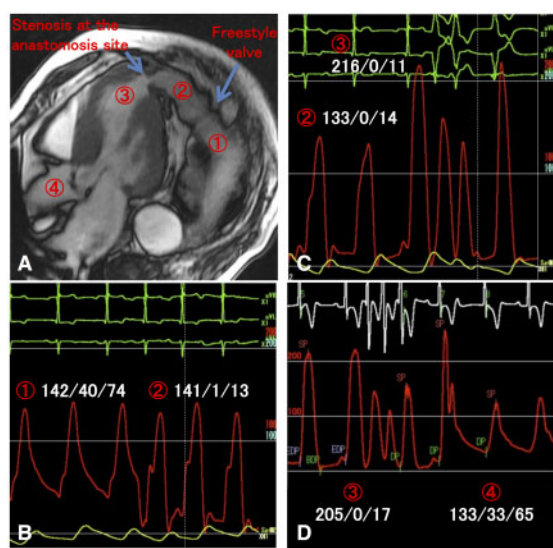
Pressure waveforms obtained during a cardiac catheterization. (A) Magnetic resonance imaging indicating the position of the end-hole catheter. (B–D) The pressures of the distal limb of the apico-aortic conduit (①), the proximal limb of the apico-aortic conduit (②), the left ventricular apex (③), and the ascending aorta (④).
